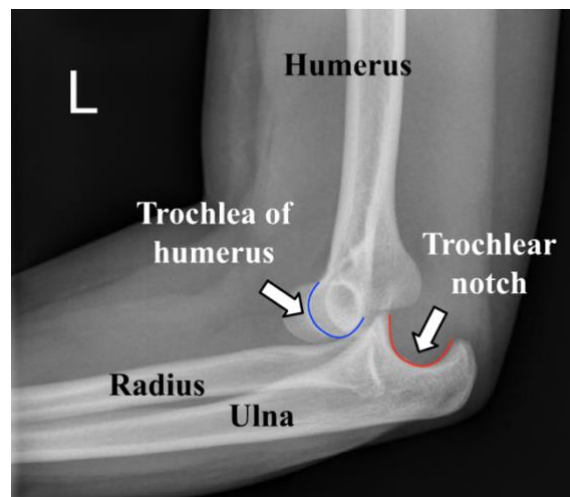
Posterior Elbow Dislocation. This shows an x-ray of a left posterior elbow dislocation of a 15-year-old girl following a wrestling match. The concerned bones are labeled in black and the displaced joint is labeled in white prior to reduction (Oppenheim, 2018).
